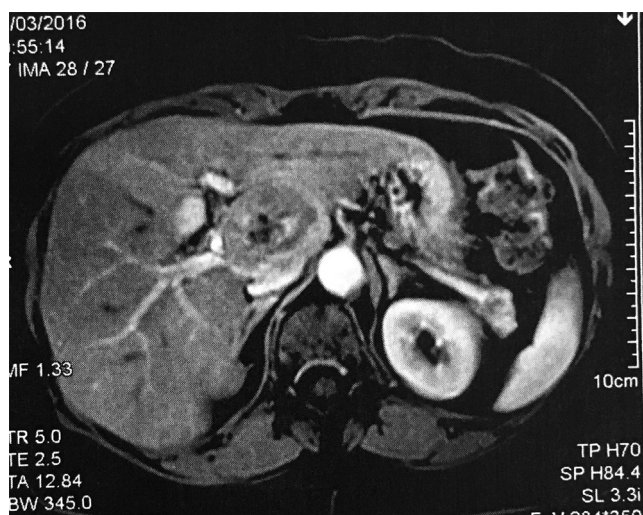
Computed Tomography showing hepatocellular carcinoma closely attached to the vena cava.
